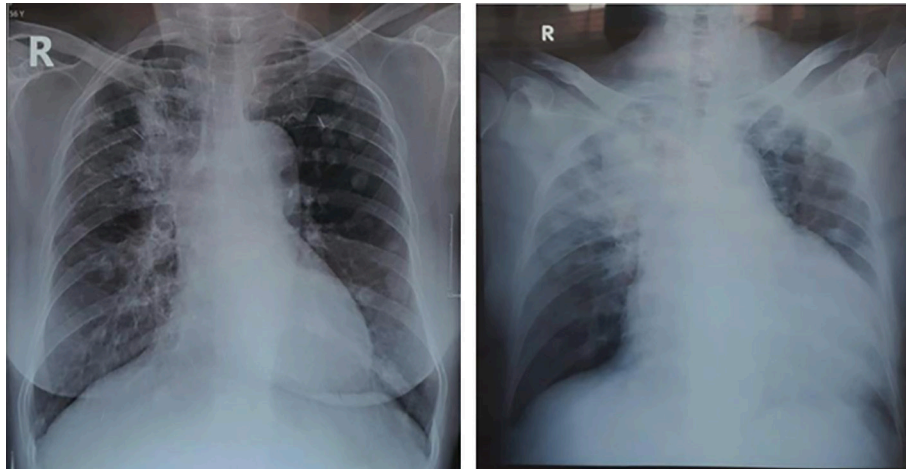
Comparison of the patient's first (October 2021) and second chest radiography (December 2021).
